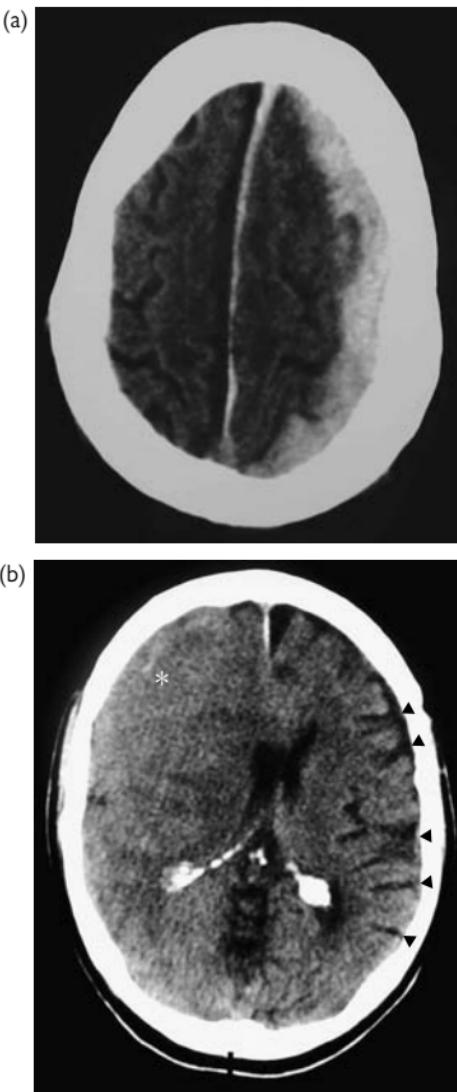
Subdural haematoma. (a)–(d): non-enhanced CT. A large subdural haematoma over the left cerebral convexity and extending into the interhemispheric fissure in (a) is hyperdense in keeping with an acute haematoma. A subacute right-sided subdural haematoma is shown in (b) with iso- to mildly hyperdense material overlying the right cerebral convexity (white asterisk) resulting in effacement and obscuration of ipsilateral cerebral sulci compared to the contralateral side (black arrowheads) and midline distortion.
